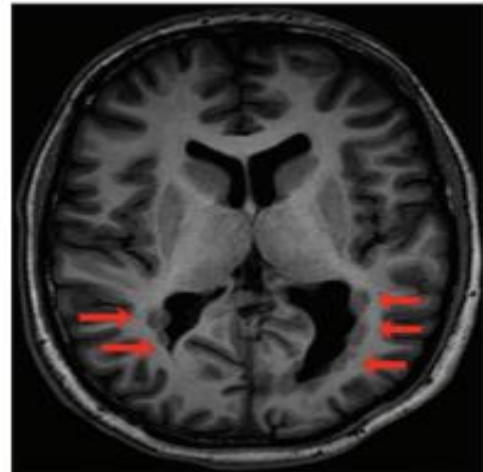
Epilepsy 3T magnetic resonance imaging of the brain showing bilateral subependymal nodular heterotopia at the level of temporal and occipital horns of the lateral ventricles.
